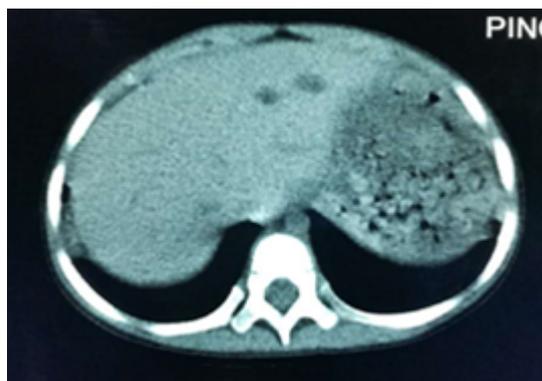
Liver computed tomography image of the cystic fibrosis patient. A liver computed tomography scan revealed a low-density lesion in the left lobe of the liver.
